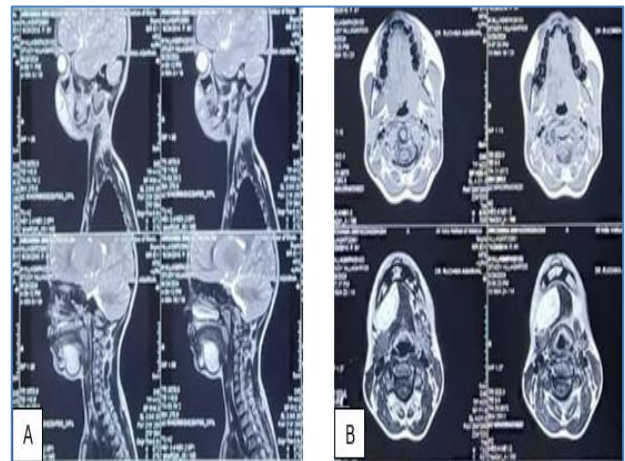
(A) Series of sagittal MRI scans of the head and neck; (B) series of axial MRI scans of the head and neck.
